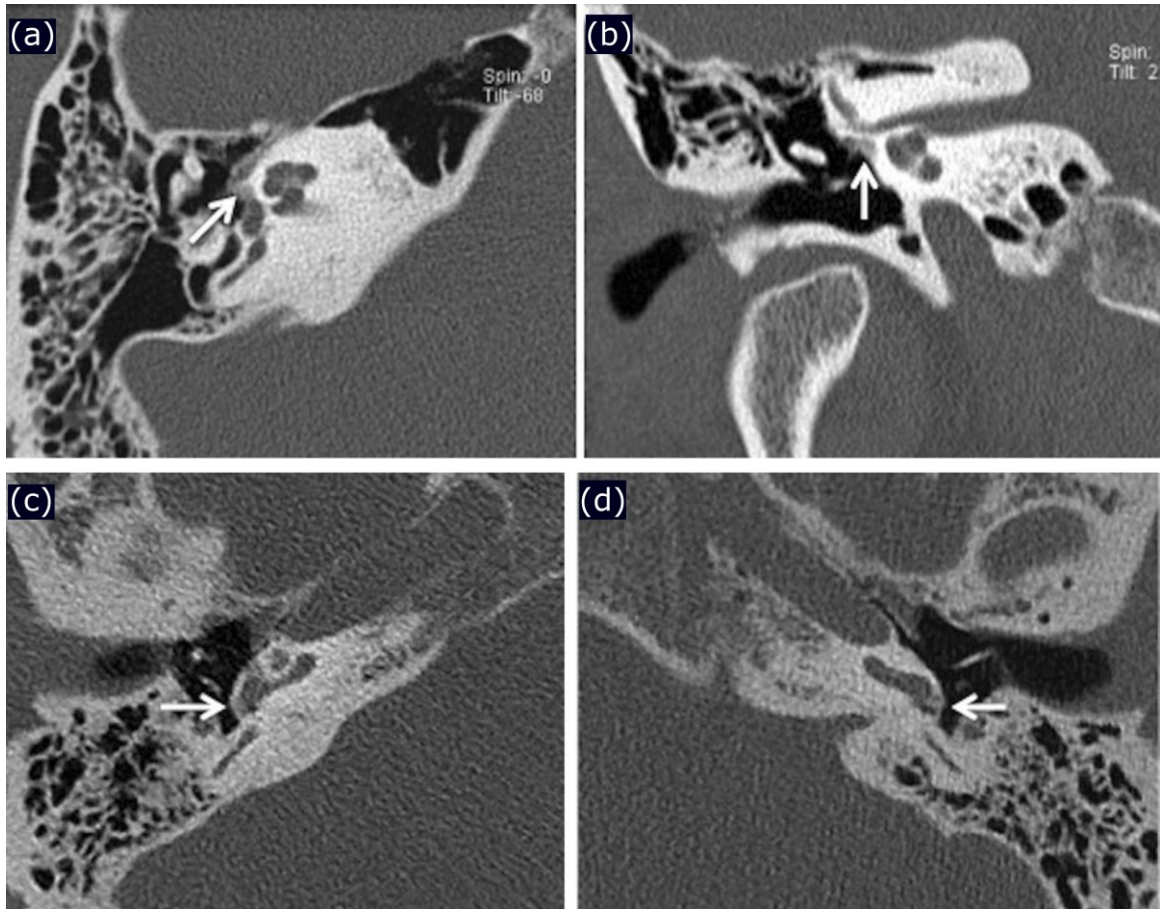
HRCT images depicting the different stages of otosclerosis. Axial (a) and (b) coronal images of the right-side middle ear of an adult patient with CHL and fenestral otospongiosis. White arrows point to the hypodense demineralized of the promontory. Right (c) and left (d) images of the middle ear in a patient with bilateral otosclerosis. White arrows point to the deposit of otosclerotic plaque causing narrowing of the round windows. From [93] and used according to the Creative Commons Attribution License [94].
